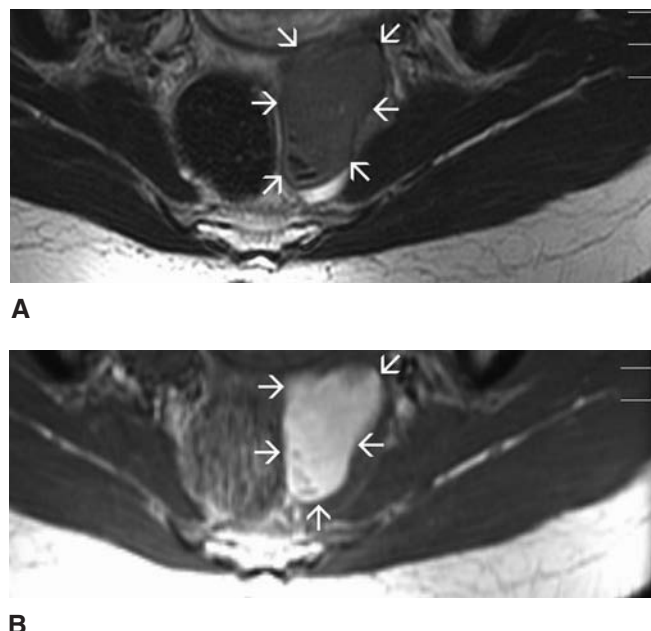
Magnetic resonance images of an endometrioma. T2- (A) and T1-weighted (B) images reveal an endometrioma (arrows) just lateral to the rectum. The findings are consistent with subacute blood, based on the bright signal on T-1 and the relatively low signal intensity on T-2 of the lesion. (Courtesy of Dr. Diane Twickler.)
